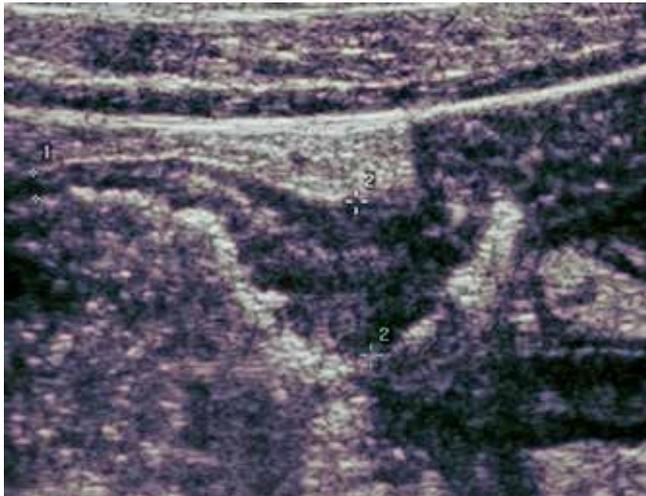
B-mode ultrasound image of the transition from normal to inflamed colon in CrD
